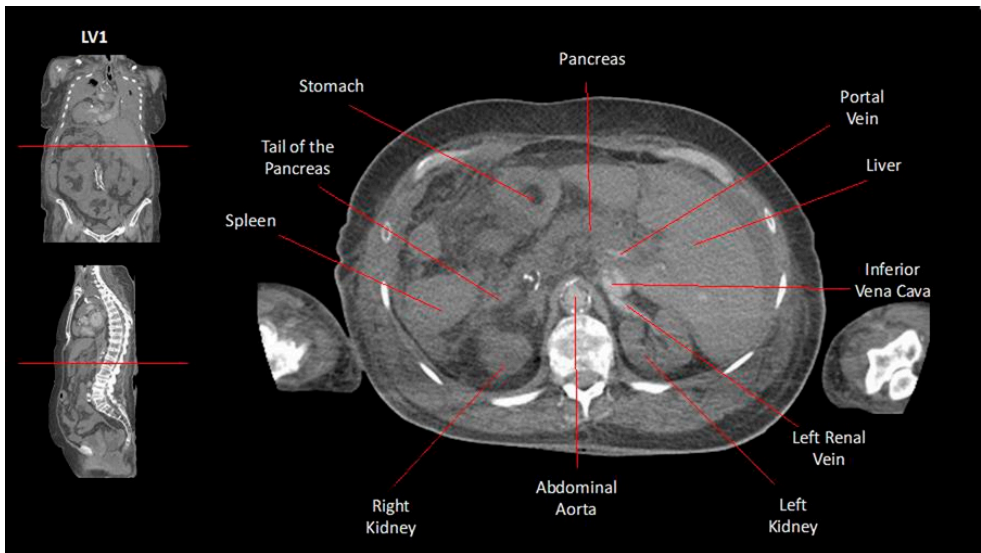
CT imaging of the abdominal viscera at the lumbar vertebral level 1 (LV1). The liver is located on the left side of the abdomen while the stomach and spleen are located on the right. The tail of the pancreas is toward the right. The inferior vena cava is to the left of the abdominal aorta and posterior to the liver. The red lines in the coronal and sagittal images denote the vertebral level.
